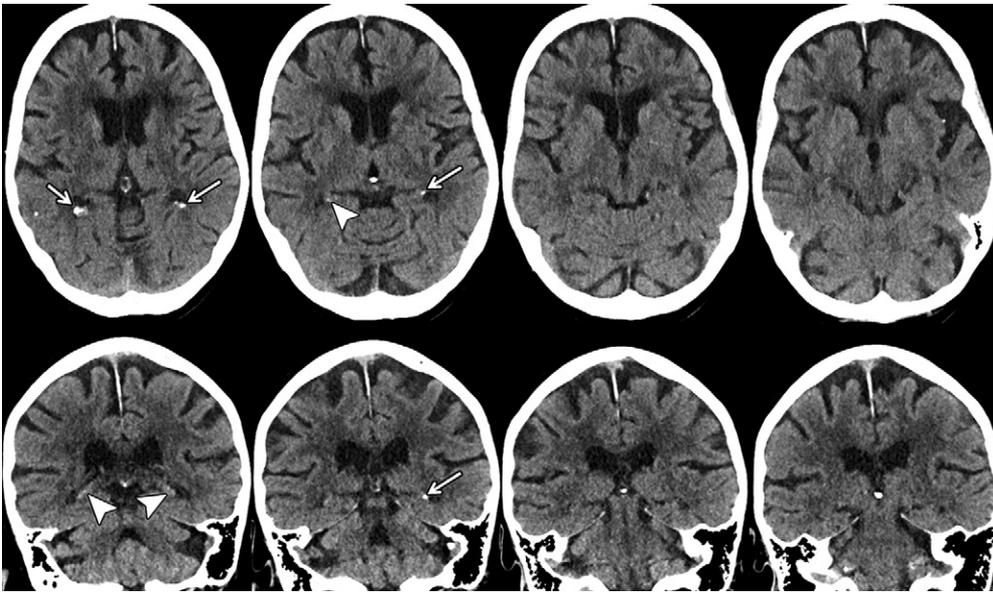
Axial and coronal CT images in 88-year-old woman show mild hippocampal calcifications (arrowheads). Arrows indicate calcifications of choroid plexus.
